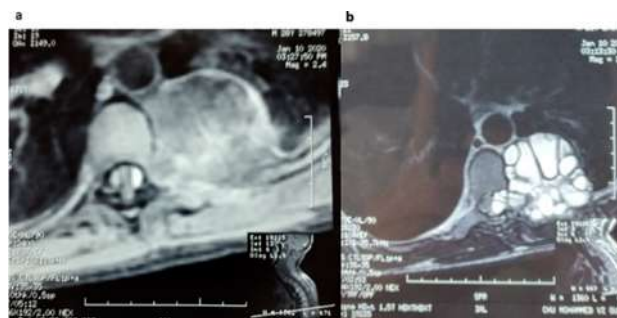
a): T1-weighted axial slice of thoracic MRI shows a hypo intense cystic formation related to the hydatid cyst, b): T2-weighted axial slice of thoracic MRI shows a hyper intense cystic formation with endocanal extension of the vesicles and compression of the marrow
